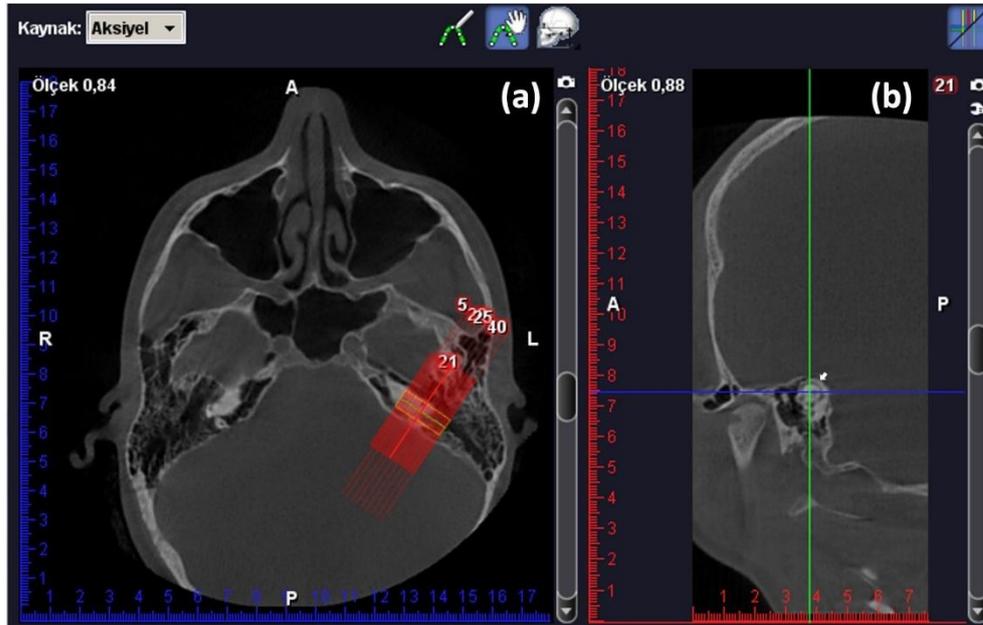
The Pöschl plane with reformatted cone beam computed tomography images (a) Angle of reformation showed on axial plane (b) Ring view of SSC indicated by arrow in Pöschl plane
